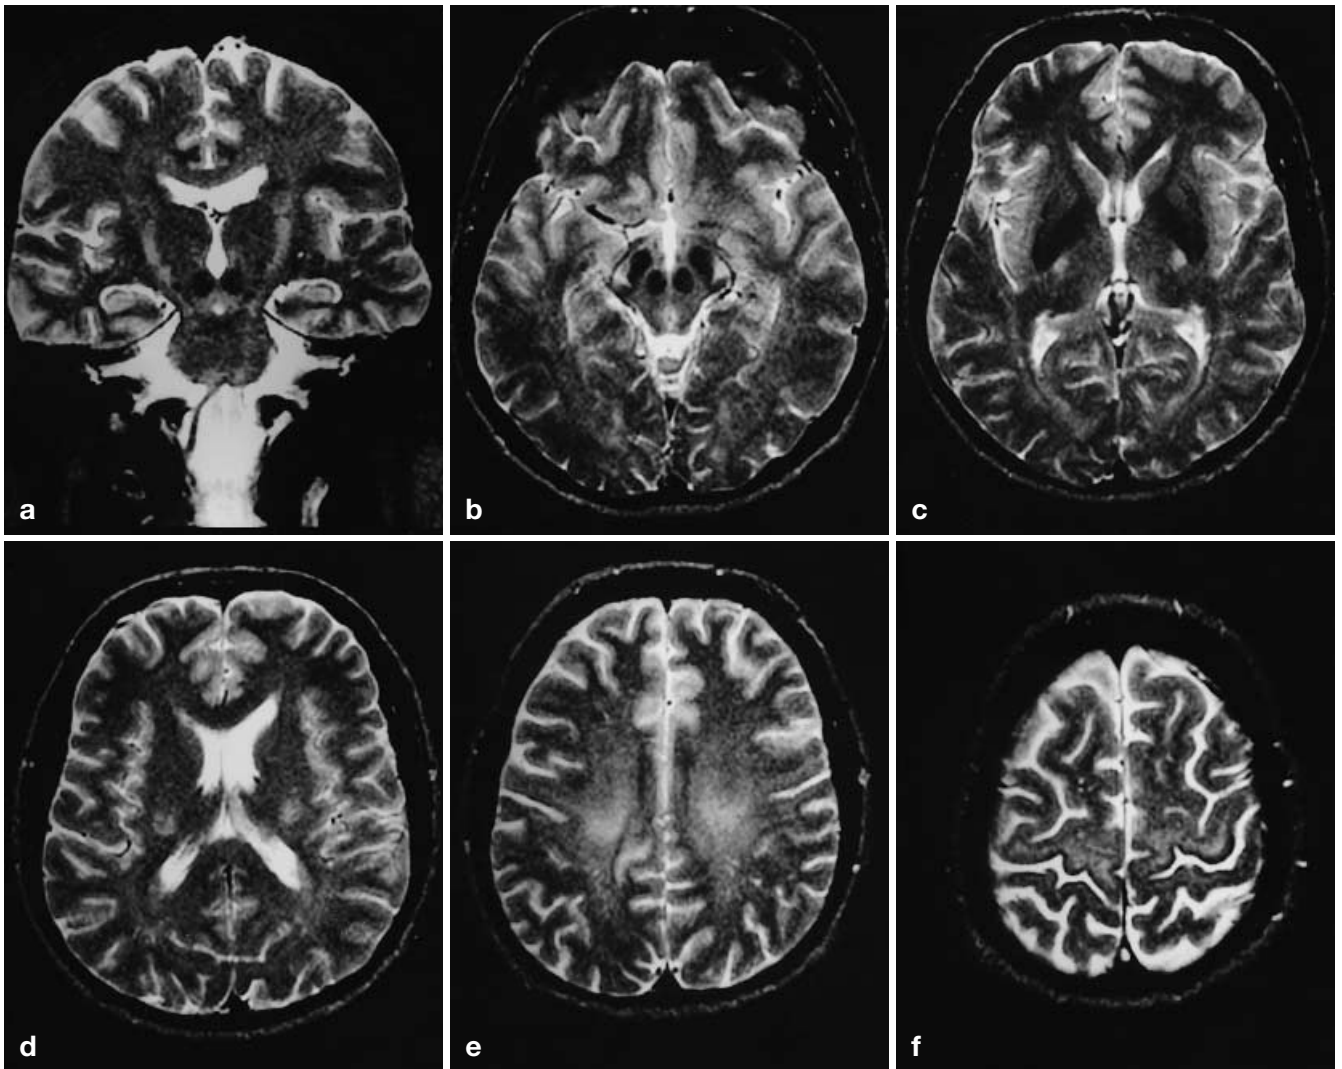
a Coronal fast spin-echo (FSE); b–f axial spin-echo (SE) T2-weighted images. Bilateral symmetric high signal of the corticospinal tract extending from the precentral gyrus to the midbrain. In the precentral gyrus, in addition to the high signal of the white matter, it is possible to observe a strip of low signal underlying the primary motor cortex (in f) due to the deposition of iron or other metals
